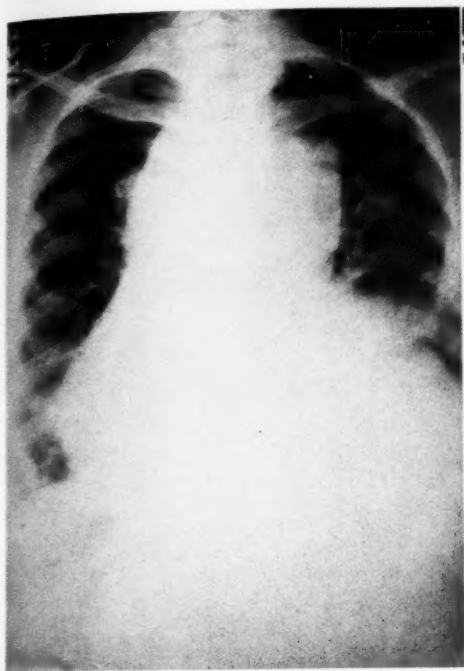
Case 4. Tumor of mediastinum, with involvement of base of right lung and elevation of right diaphragm. (Before X-ray therapy, April, 1929.)
